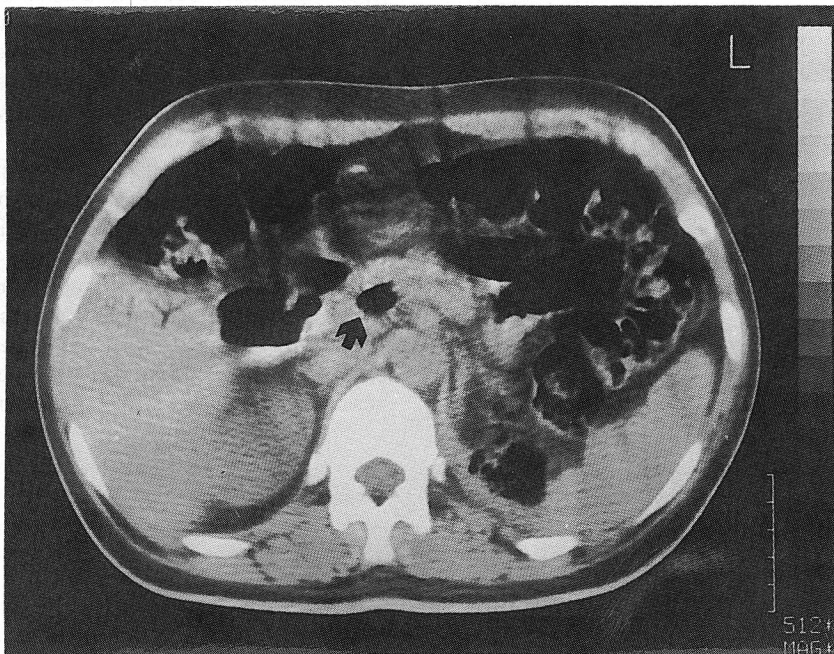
CT scan shows gas in the superior mesenteric vein (arrow)
